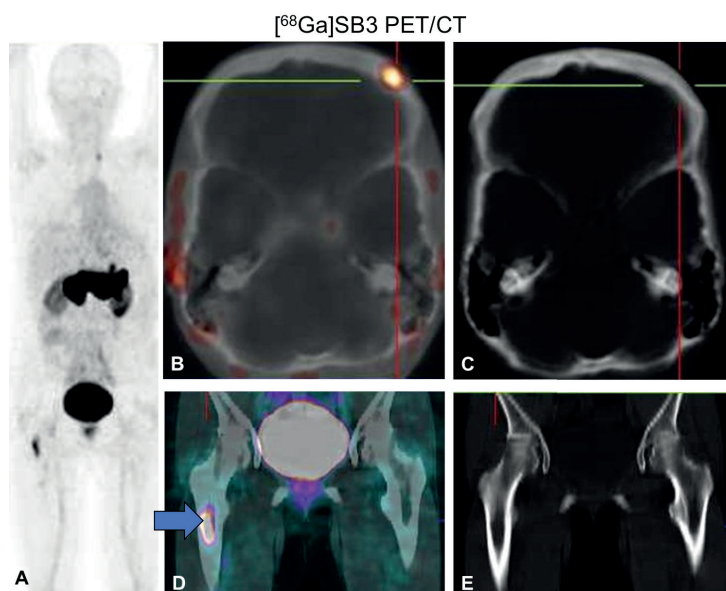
[⁶⁸Ga]SB3 scan in a breast cancer (BC) patient (number 6), demonstrating GRPR-positive bone metastasis in the skull: frontal bone on the left side (B, SUV_{max} 2.4) and bone marrow metastasis in the right proximal femur (D, arrow, SUV_{max} 7.8), both negative on CT (C, E). A MIP; B fused axial PET/CT image; C, E axial CT images; D fused coronal PET/CT image.
